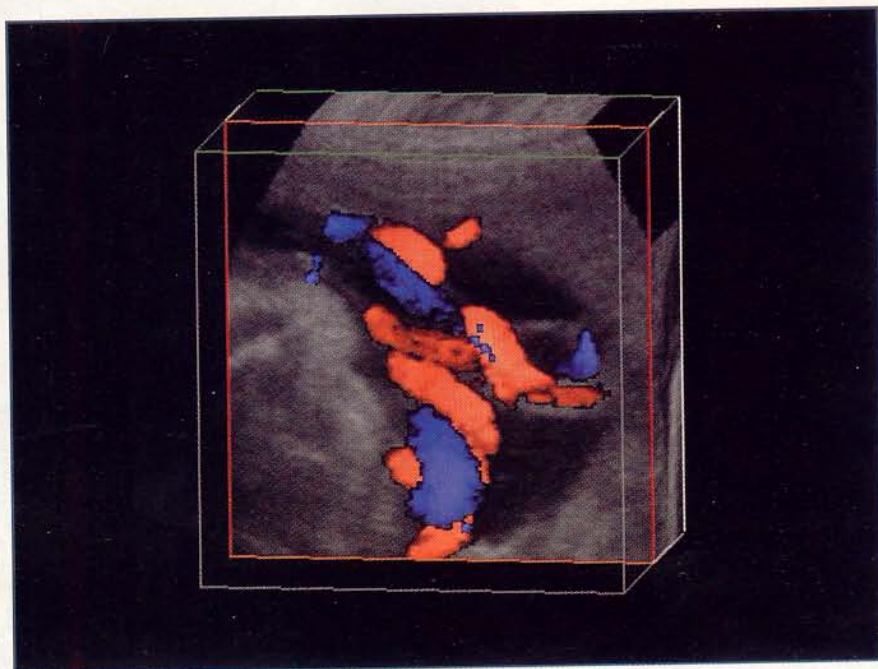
In a color Doppler ultrasound image, blood flowing toward the ultrasound probe is represented in red and that away from the probe in blue.
